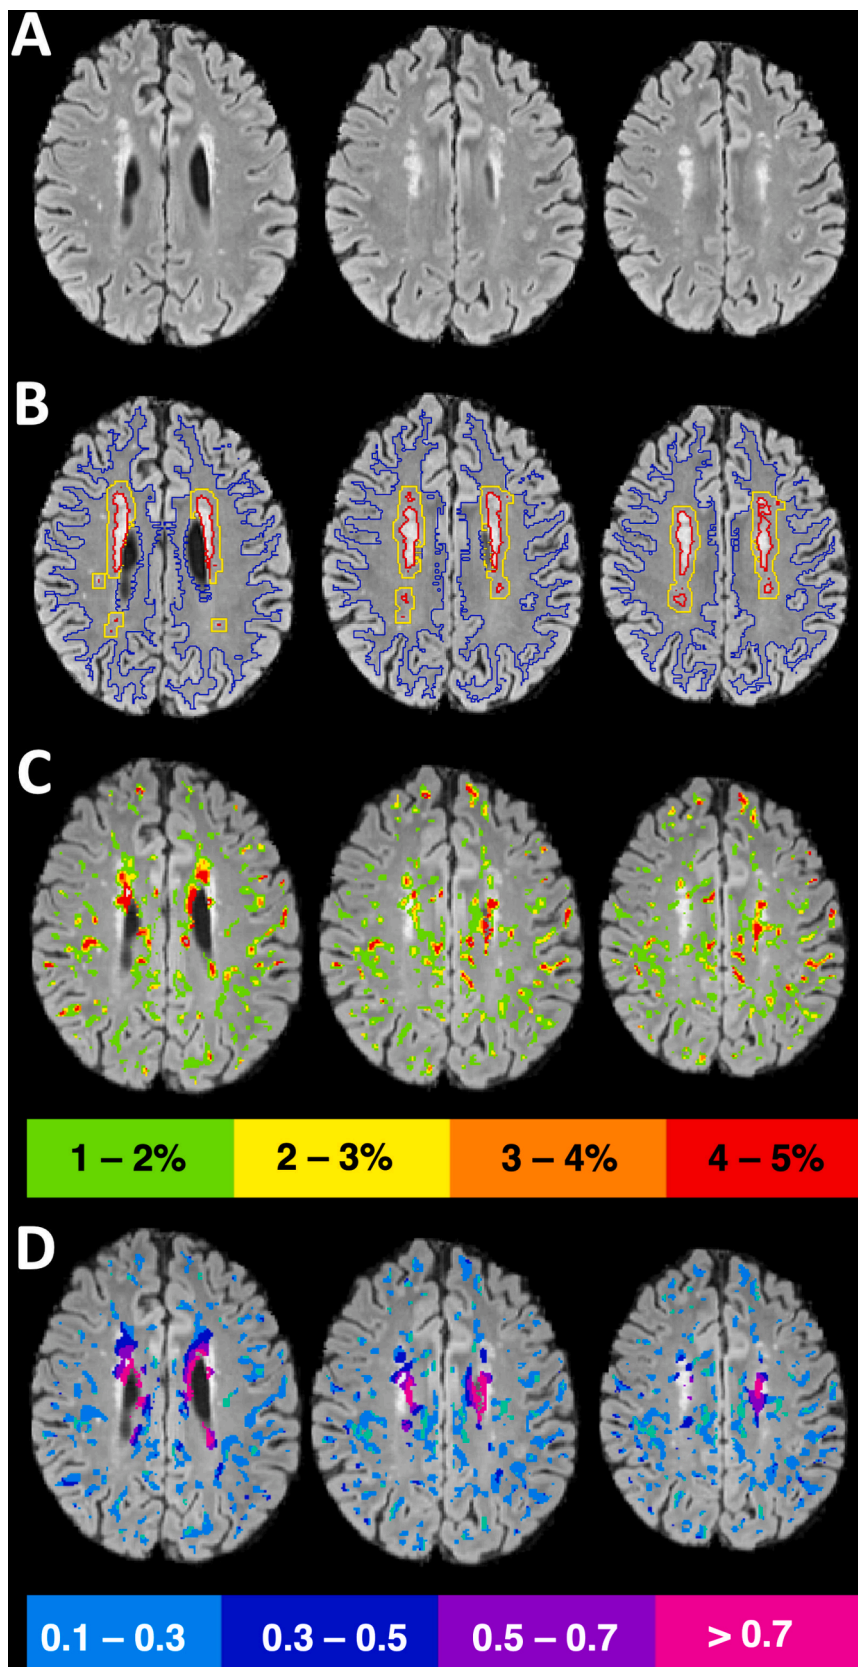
Methods. A) FLAIR axial slices show white matter hyperintensities (WMH) in the periventricular area and the corona radiata. B) Tissue was segmented into WMH (red), WMH penumbra (yellow), and normal appearing white matter (blue). C) Regions of relative blood–brain barrier disruption (BBBD) across all white matter were divided into echelons (only 4 pictured here for clarity) and overlaid on the FLAIR image. D) Within each echelon of BBBD, the mean free water (FW) was calculated, colorized, and overlaid on the FLAIR image. In regions of increased BBBD, mean FW was higher, demonstrating colocalization between these two biomarkers. (For interpretation of the references to color in this figure legend, the reader is referred to the web version of this article.)
